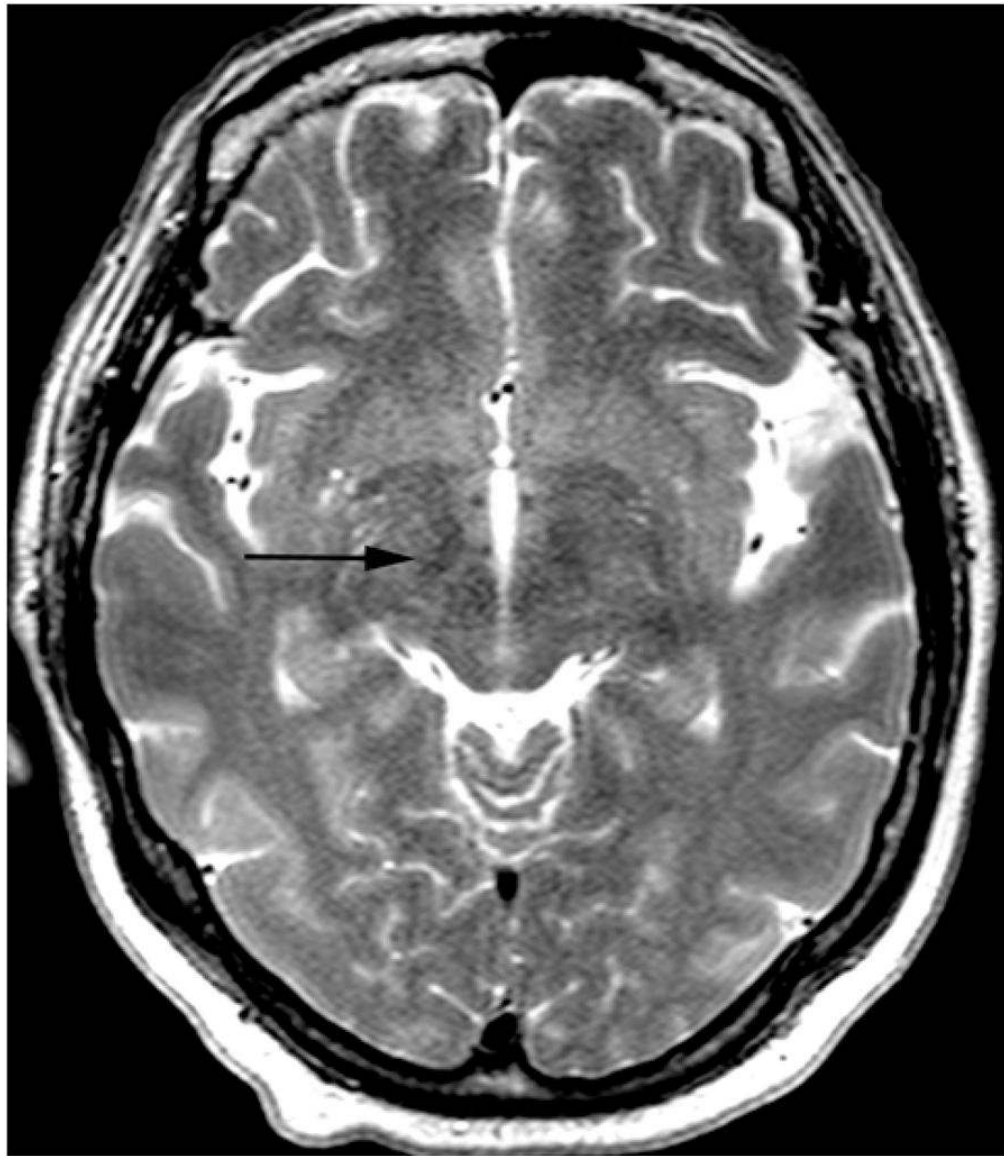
Axial MR image used to define the target in the dorsolateral STN (*black arrow* indicates right STN; MR protocol 3).
